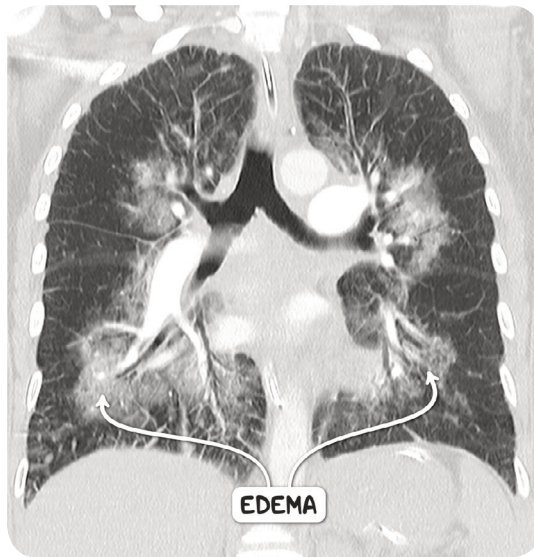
A CT scan of the chest in the coronal plane demonstrating the peribronchovascular distribution of acute pulmonary edema.
